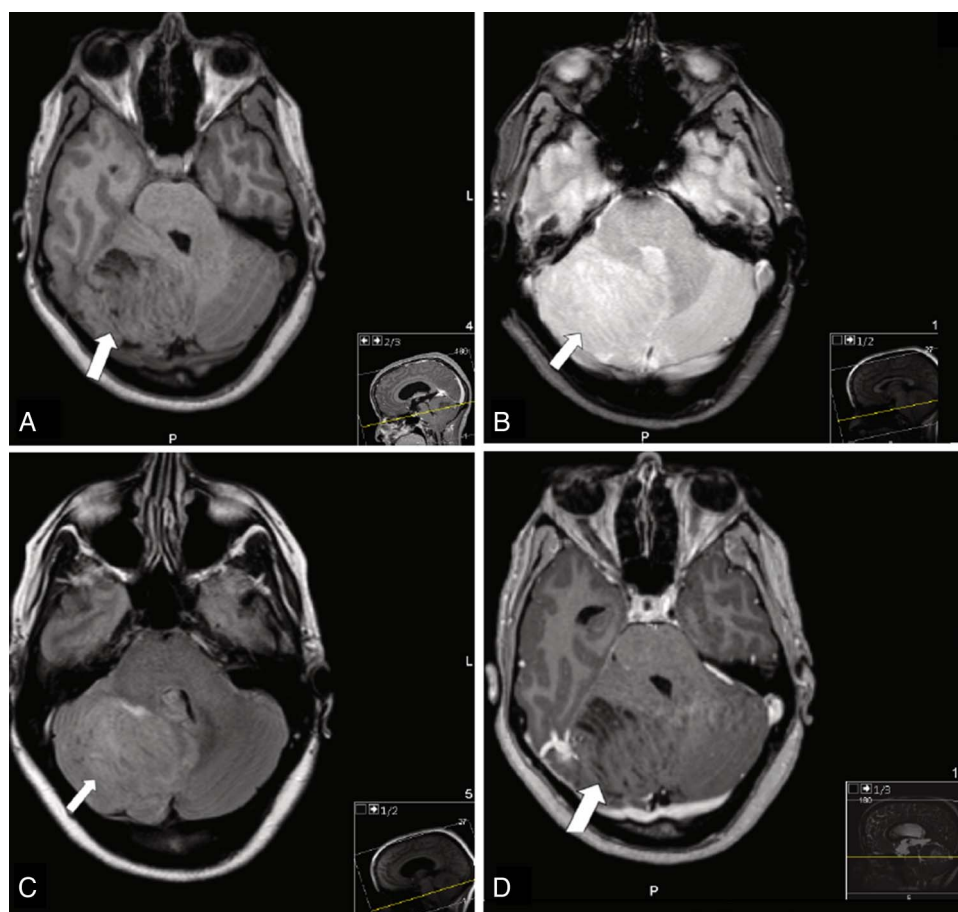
Axial MRI presented the typical striated appearance, with alternating hypointense and isointense bands (arrow) in T1-weighted (T1-W) images (A) and alternating high-intensity and normal-signal-intensity bands (arrow) in T2-weighted (T2-W) images (B). Axial fluid-attenuated inversion-recovery (FLAIR) MRI (C) showed global hyperintensity of the lesion (arrow). Axial T1-W-MRI with intravenous gadolinium (D) showing no enhancement of the cerebellar tumour (arrow). The typical striated pattern on T1-W images is preserved and well demonstrated here.
